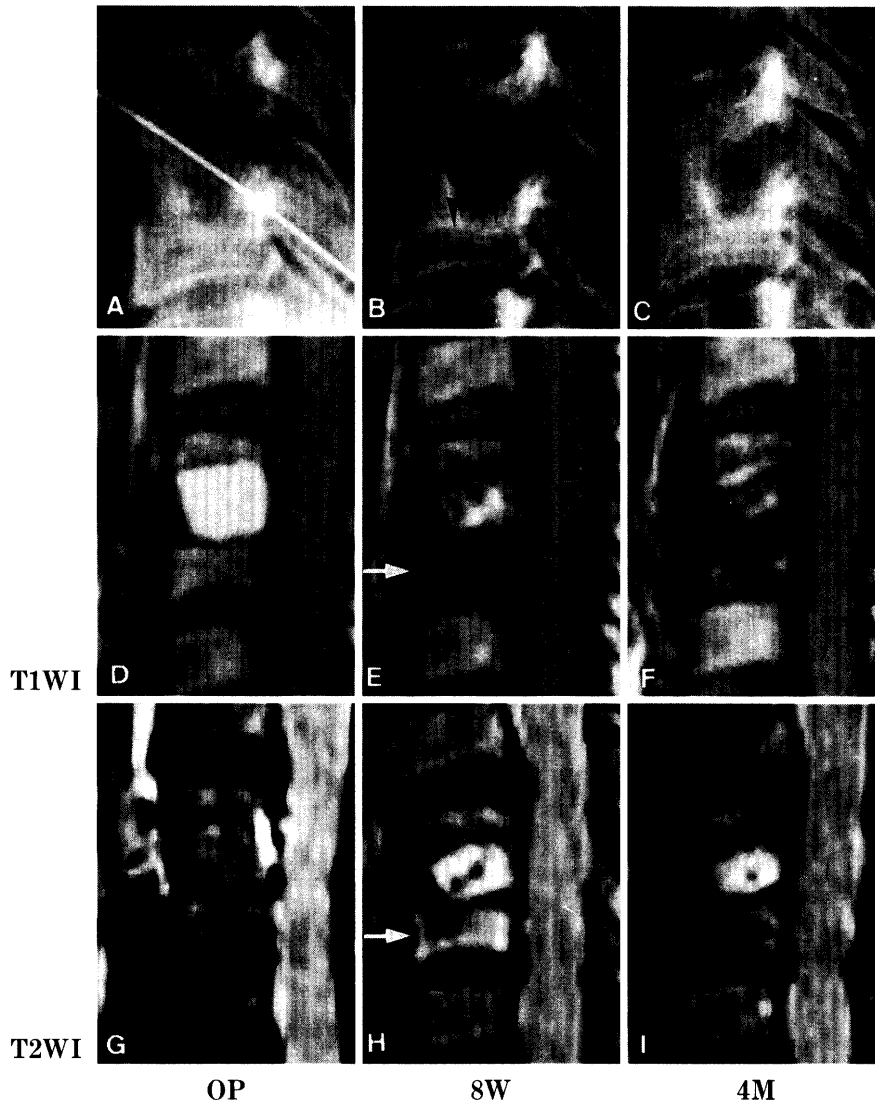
At eight weeks after surgery, the bone graft is compressed into the lower matrix (B), and a low intensity signal on the T1-weighted images (E) and a high intensity signal on the T2-weighted images (H) of the lower vertebra persists, exhibiting a PU2 pattern. These changes disappear at the time of complete bony union at four months (F and I).
